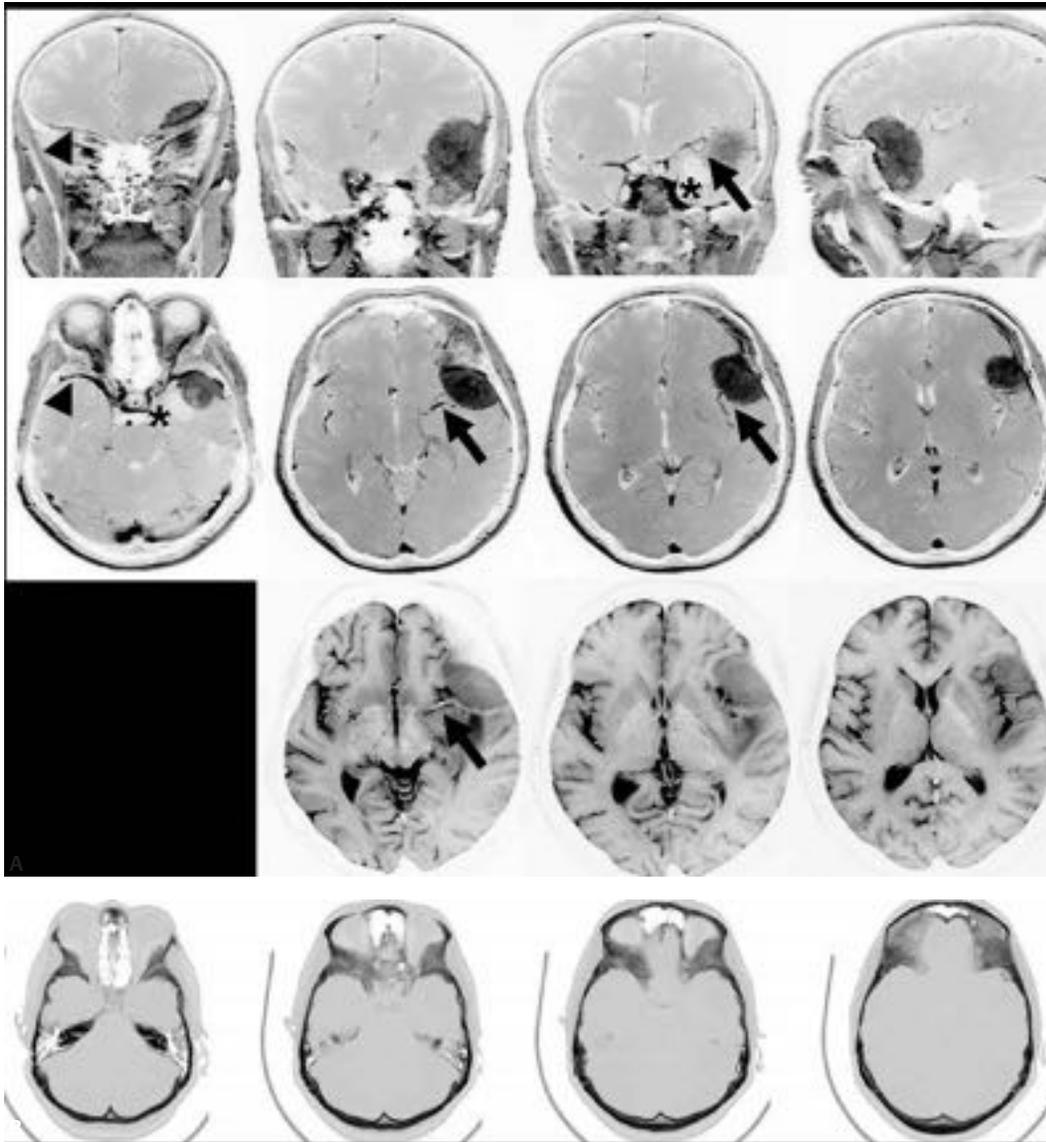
A bilateral sphenoid wing meningioma with a left-sided, medium-sized globular pterional (lateral wing) component. The tumor became symptomatic with seizures. See Fig. 23.8 for the corresponding intraoperative findings. (A) T1-weighted and axial T2-weighted images depicting a tumor mass centered on the left lateral sphenoid ridge, and tumorous infiltration of the ipsilateral as well as the contralateral dura overlying the right sphenoid ridge (*arrowhead*). The dorsomedial border of the tumor mass appears related to the middle cerebral artery and its branches (*arrows*). There is also a (nonneoplastic) cyst located immediately adjacent to the medial surface of the tumor (*). (B) Computed tomographic scans show bilateral and extensive involvement of the sphenoid bone largely sparing the left anterior clinoid process. Copyright M. Simon and J. Schramm, reproduced with permission.
